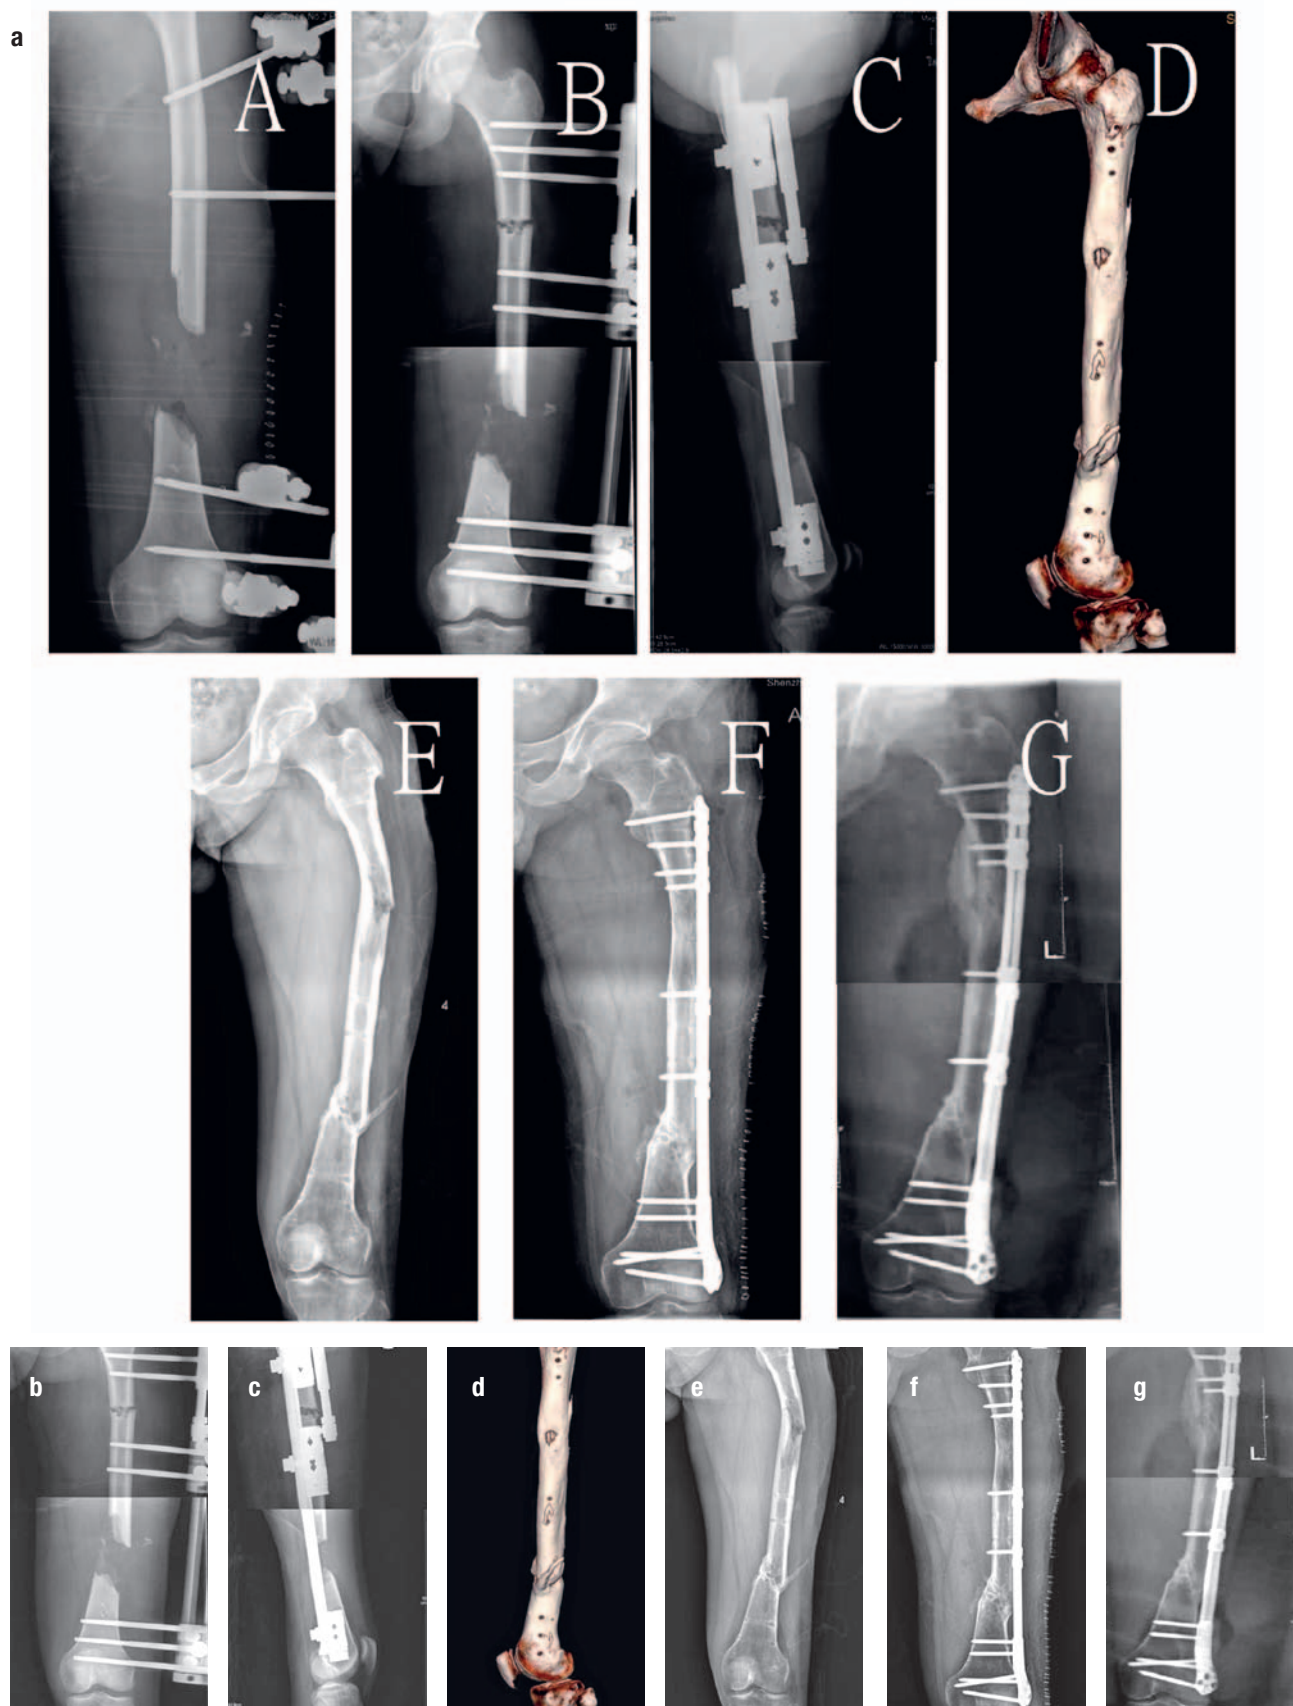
32-year-old male patient with open bone defect of left femur underwent bone transport: (a) the open fracture debridement is followed by anteroposterior X-ray of the femur; (b) the osteotomy transport is followed by anteroposterior X-ray of the femur; (c) the osteotomy transport is followed by lateral X-ray of the femur; (d) the removal of external fixation is followed by three-dimensional reconstruction of the femoral CT; (e) the internal fixation is followed by anteroposterior X-ray of the femur; (f) anteroposterior X-ray of the femur 3 months; (g) the anteroposterior X-ray of the a half after operation.
